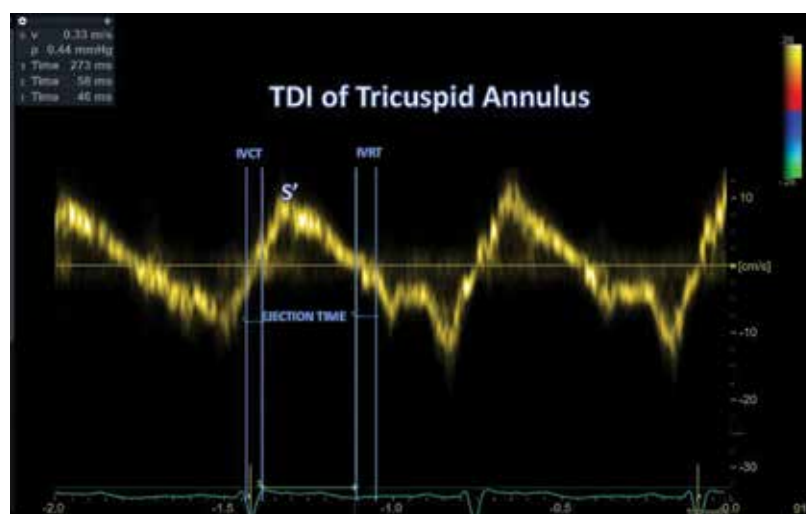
Showing the tissue doppler imaging based RIMP (Tei index) calculated by Isovolumic contraction time + Isovolumic relaxation time/ ejection time $RIMP = (IVRT + IVCT) / ET$
